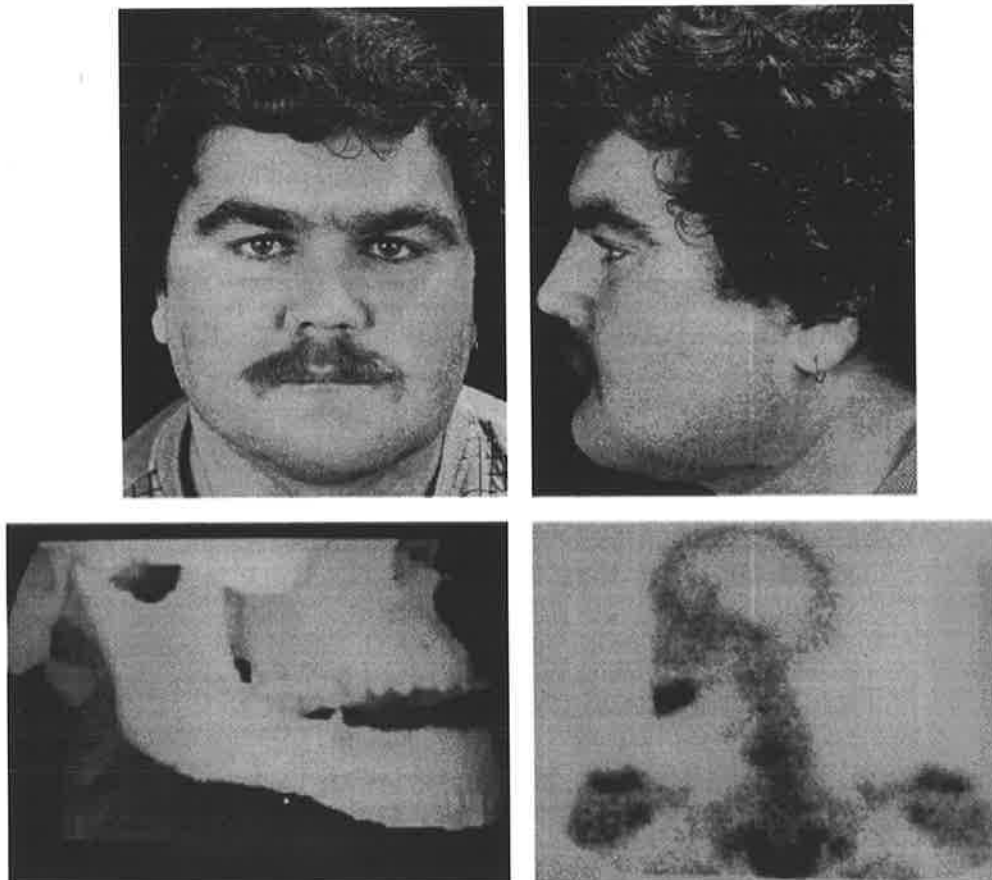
Case 4. A 24-year-old man with a squamous cell carcinoma of the alveolus showing the postoperative result (above) and the three-dimensional CT scan (below, left) of the angle-to-angle mandibular reconstruction at 6 months. (Below, right) The bone scan at 3 days shows good uptake of the isotope.
